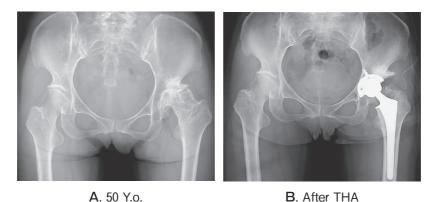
X-ray imaging in the CCR case before and after THA at age 50.
